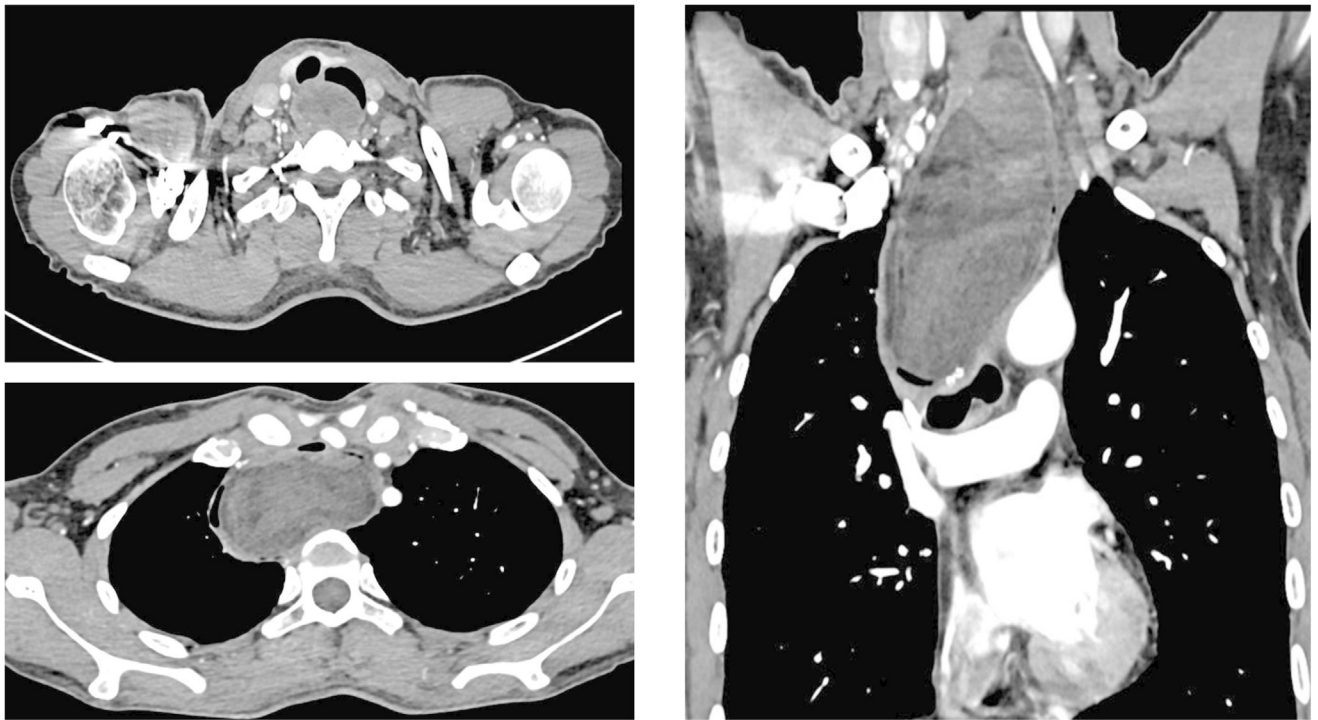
Computed tomography scan of the recurrent esophageal liposarcoma.
